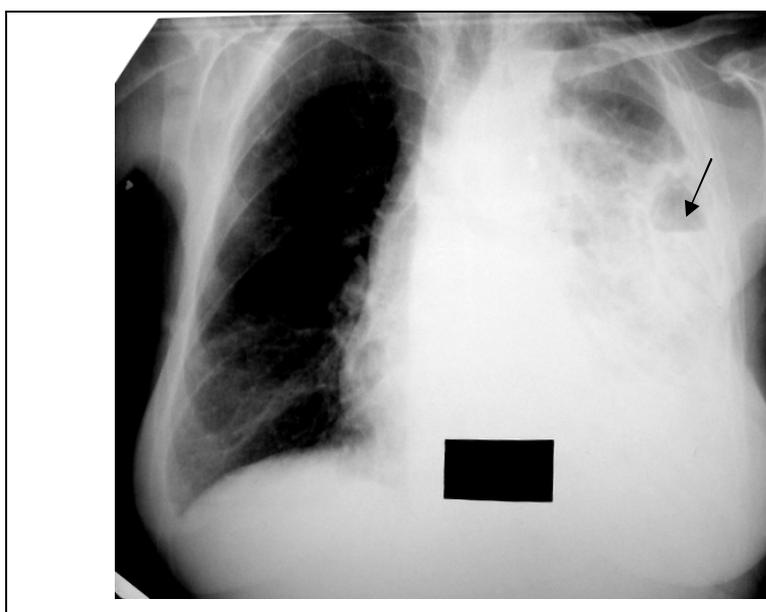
The frontal chest radiograph.
